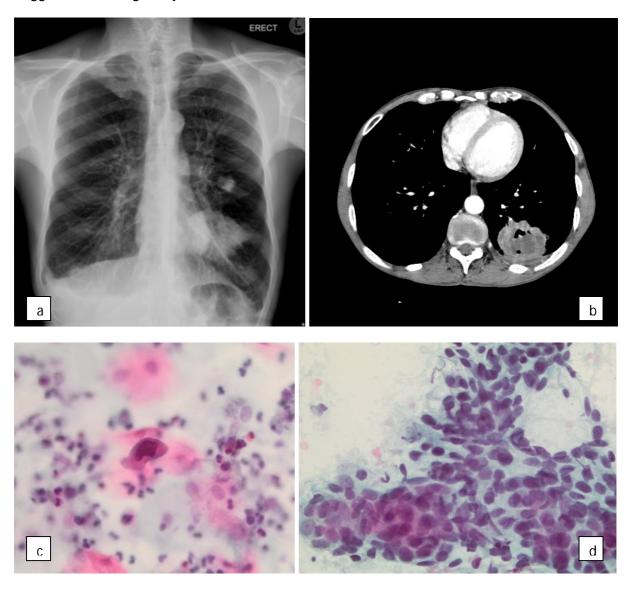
Large heterogeneously enhancing lesion and associated pleural reaction in the posterior segment of the left lower lobe on chest X-ray (a) and CT (b).
